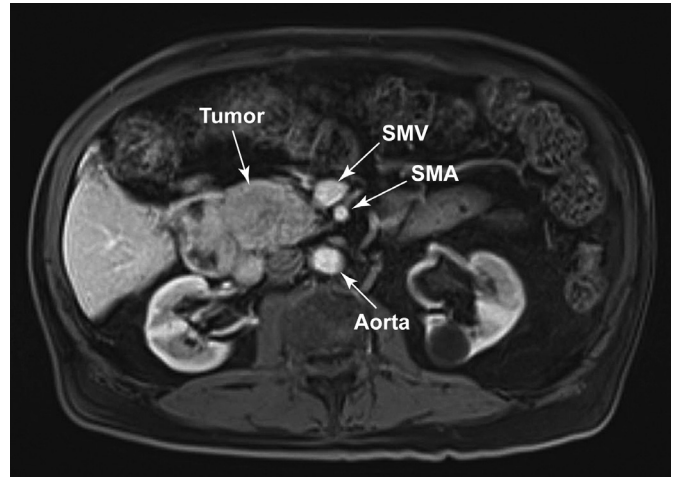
MRI showing 5.4 x 3.8 cm hyperintense mass in the uncinate process of the pancreas without evidence of metastatic disease.
